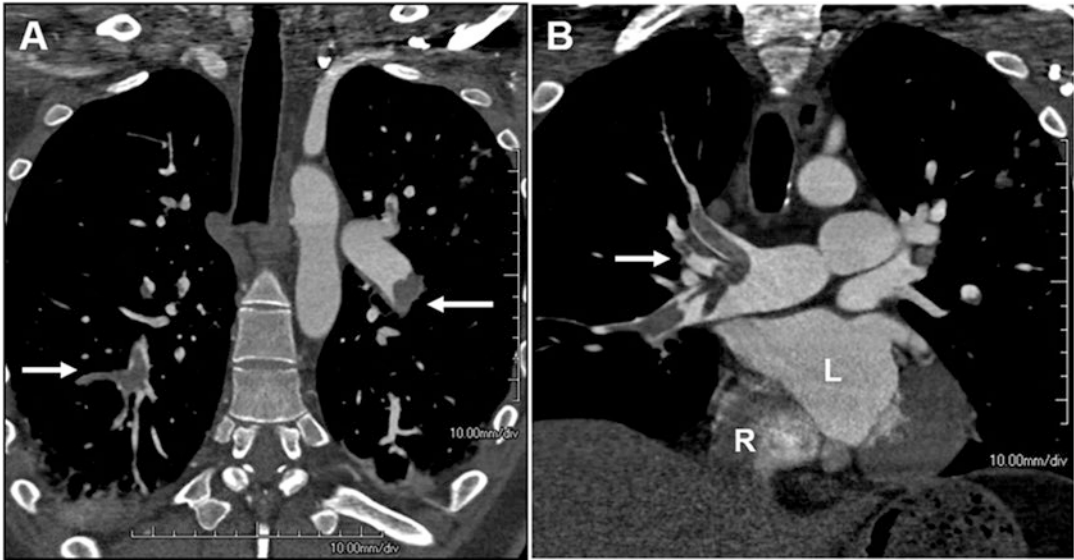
Computed tomographic pulmonary angiogram demonstrating bilateral filling defects in the branches of the pulmonary arteries (*white arrows*), which are diagnostic of acute pulmonary embolism. (a) A “four-chamber
